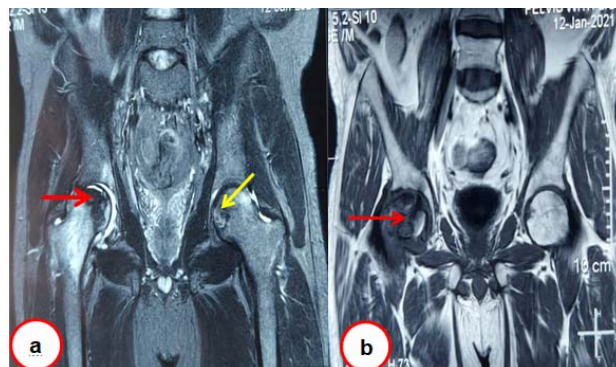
MRI Images (a) STIR sequences showing destruction of right femoral head with collapse and osteoarthritic changes (red bold arrow), osteonecrosis of left femoral head (yellow bold arrow) (b) T1 weighted images showing osteonecrosis of right femoral head (red bold arrow)
